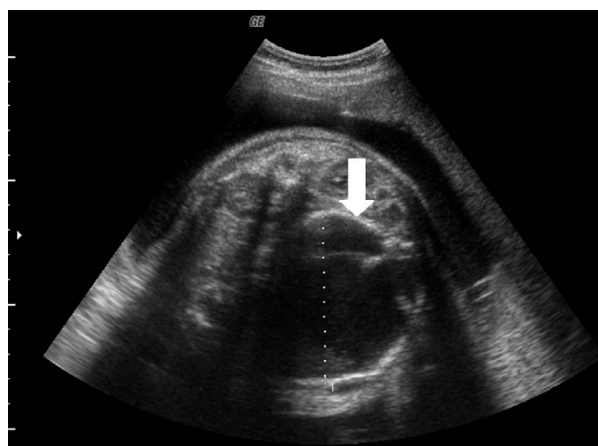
In case 13, a large intra-abdominal pseudocyst (arrow) is seen on prenatal ultrasound. The cyst is well encapsulated and measures 6.72 cm in diameter. The large cyst resulted in lung volume compression. After delivery, ileal atresia was noted during surgery and left lung hypoplasia was diagnosed postnatally.
